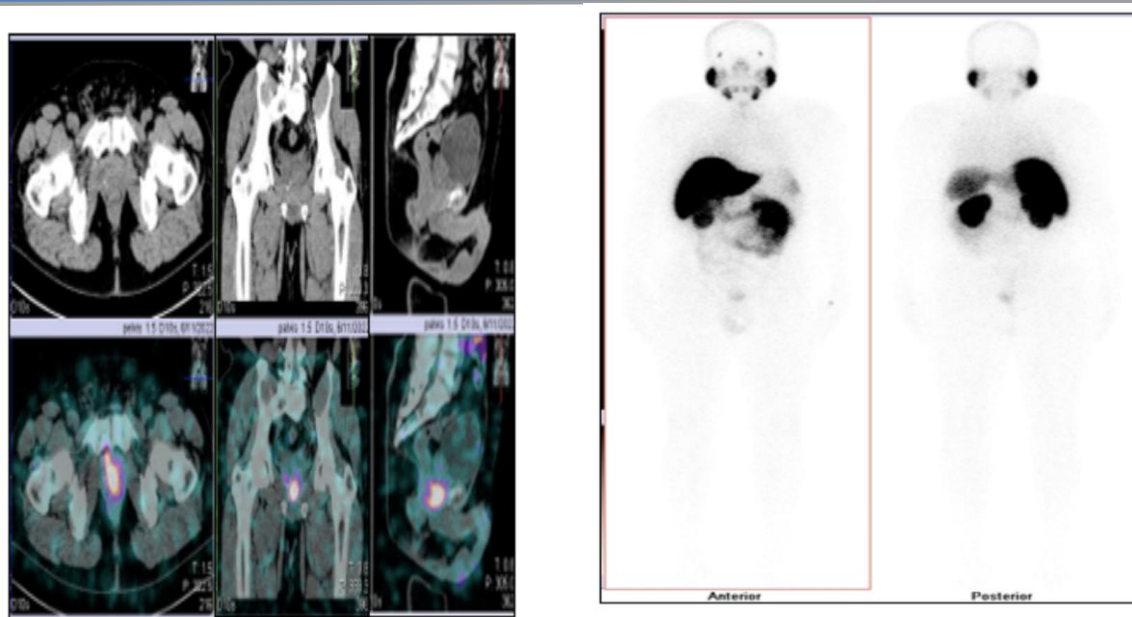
99mTc PSMA SPECT/CT trans-axial, coronal and sagittal views (A) of the pelvis and planar anterior and posterior view (B) show Active PSMA uptake was seen at the prostatic gland involving the right peripheral and transitional zone of the mid gland and apex.
